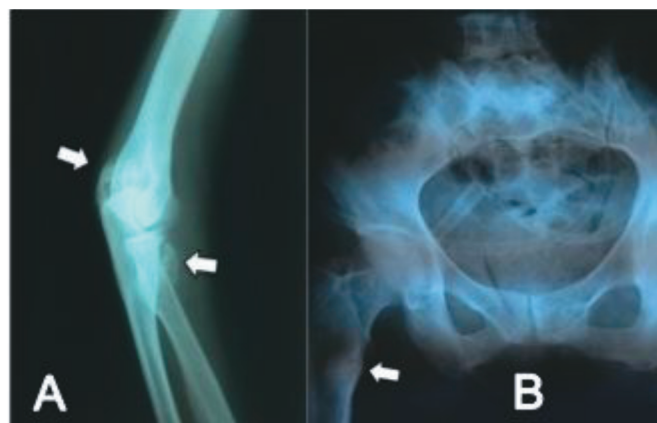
Lateral radiograph of the right elbow showing heterotopic ossification (A) and anterior-posterior pelvis radiograph designating the looser zone (Milkman's pseudofracture) of bilateral femoral necks (B).
